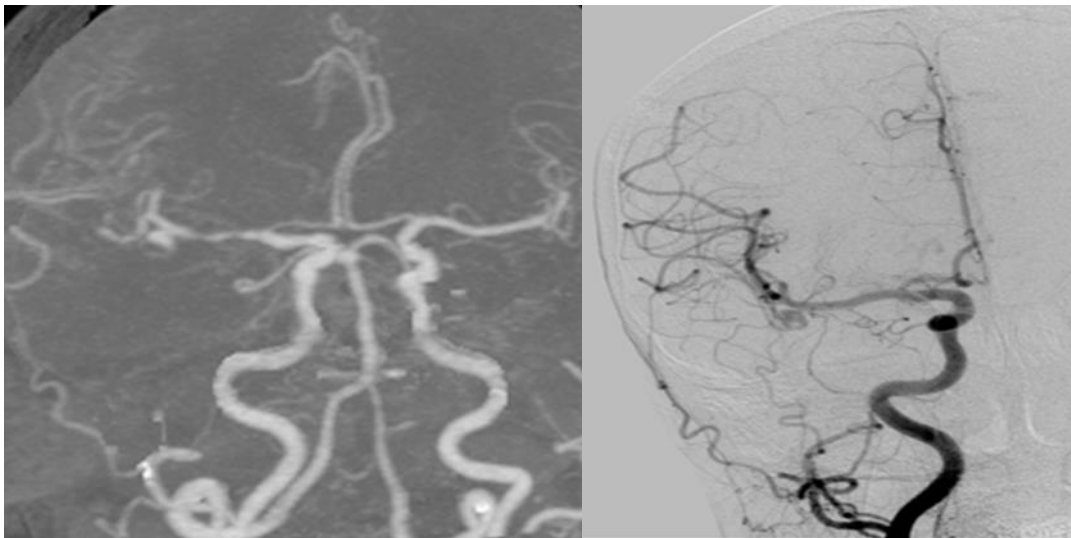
Initial CTA and /DSA of M1 and distal M2 before EVT, 63-year old patient with ruptured aneurism of medial cerebral artery, VS on M1 and M2 segments, not treated with IV Nimodipine, there is spontaneous VS relaxation
